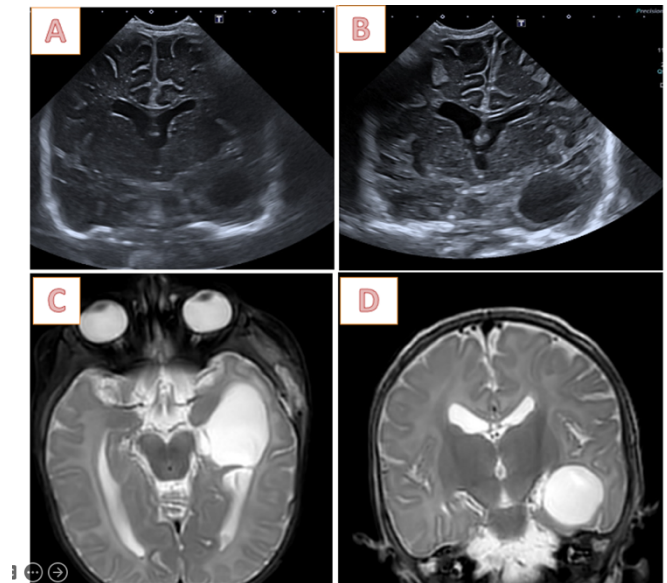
Postoperative images. (A) First intraoperative transfontanellar ultrasound showing a marked reduction in the size of the left temporal cystic lesion compared with the previous MRI. The current measurement is 3.6 × 2.1 × 2.4 cm (AP × T × CC). (B) Second intraoperative transfontanellar ultrasound showing further reduction in cyst size compared with the previous ultrasound, measuring 3.2 × 2.1 × 2.1 cm (AP × T × CC). (C–D) Postoperative MRI (axial and coronal cuts, T2 FSE PROPELLER sequence) demonstrating a decrease in the size of the cystic lesion closely related to the left temporal lobe, as well as reduction of the edema in the white matter of the temporal pole, with maximum diameters of 3.4 × 2.3 × 2.3 cm.
